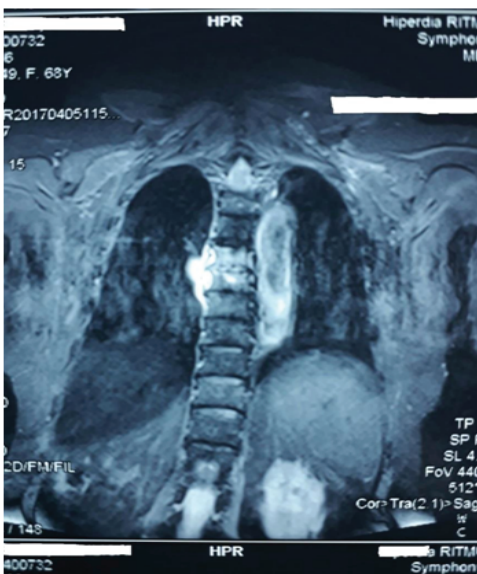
RMN and CT spine scan
